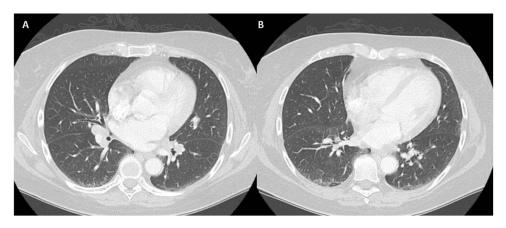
Sequential imaging of a patient with an HER2+ breast cancer, enrolled in a clinical trial, treated with neoadjuvant epirubicin and cyclophosphamide followed by carboplatin and paclitaxel plus trastuzumab and pertuzumab in combination with atezolizumab. Pre-operative CT scan performed at the end of neoadjuvant chemotherapy showed multiple mediastinal lymph node formations (A). Biopsy done during the endobronchial ultra sound showed a granulomatous sarcoidotic-like inflammation. The multidisciplinary team suggested an immunotherapy related sarcoidosis. Atezolizumab was discontinued. The CT scan performed 6 months later showed radiological resolution of pulmonary inflammation, and dimensional reduction of all lymph nodes (B).
